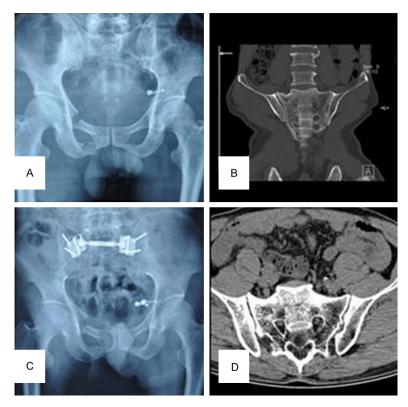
A 57-year-old male sustained pelvic fracture (OTA 61-C1) due to fall from height. The posterior pelvic ring was fixed with MIAP. A. Preoperative pelvic radiograph demonstrated sacral fracture associated with fractures of pubic rami (anteroposterior view). B. Preoperative CT image demonstrated right sacral compressed fracture (coronal view). C. Pelvic radiograph was taken at three months postoperatively (anteroposterior view). D. Pelvic CT was taken at thirty-one months postoperatively.
